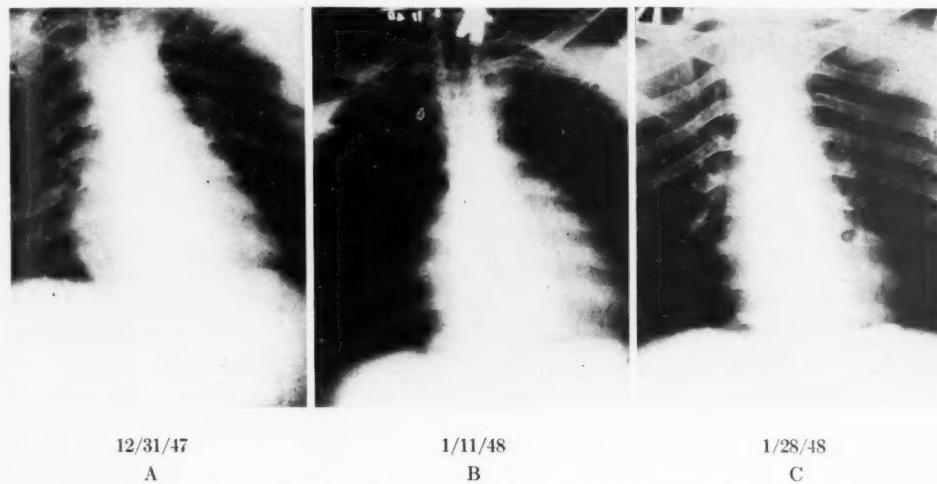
Bedside anteroposterior chest x-rays of a patient with contusion of the heart.
